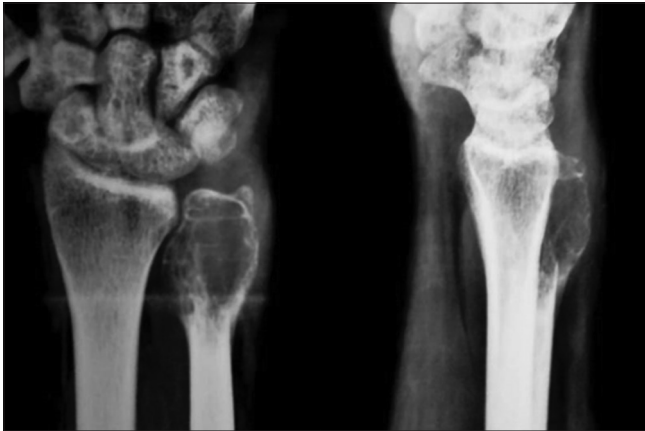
Anteroposterior and lateral radiographs showing an expansile osteolytic lesion in the distal ulna
